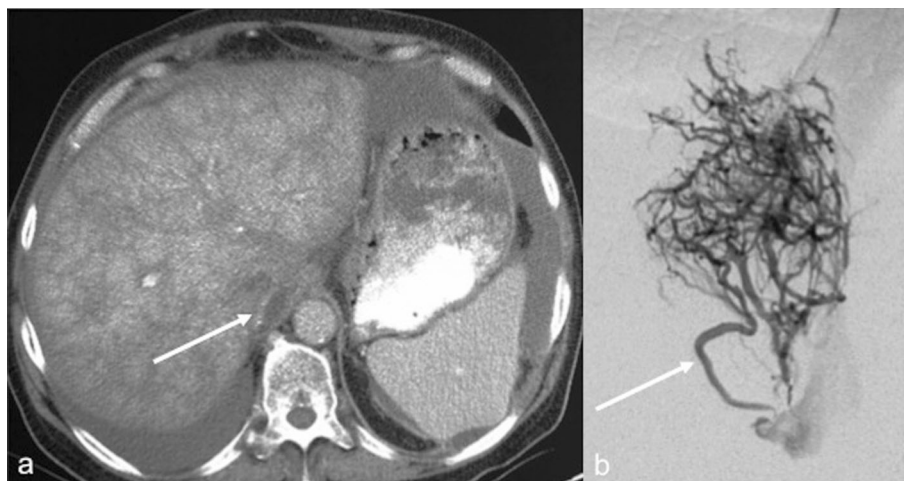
A 17-year-old female smoker who presented with abdominal fullness after beginning oral contraceptives. a Axial contrast-enhanced CT at the level of the upper abdomen shows markedly heterogeneous enhancement of the hepatic parenchyma and only trace enhancement within the inferior vena cava (arrow). No flow was seen
